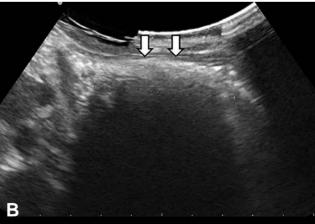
Ultrasonography of the abdomen. Multiple target lesions are detected in the small bowel (arrows, \mathbf{A}). There is a 5 cm-long echogenic lesion with posterior shadowing in the stomach, suggesting the trichobezoar (arrows, \mathbf{B}).
